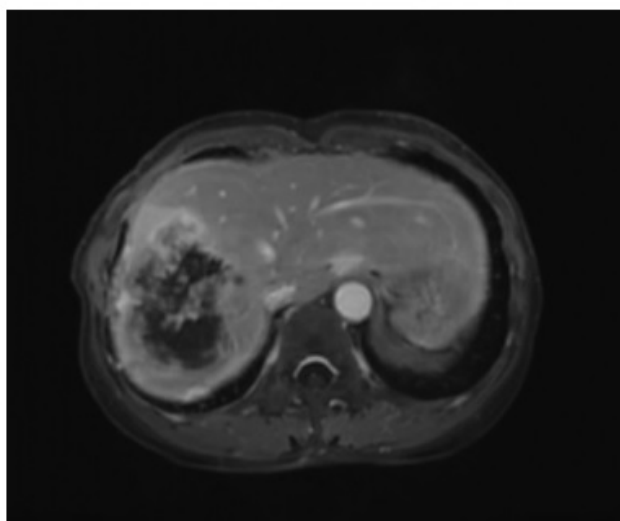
The MRI image of the single recurrence after three years of its appearance as a <2cm lesion in the liver.
